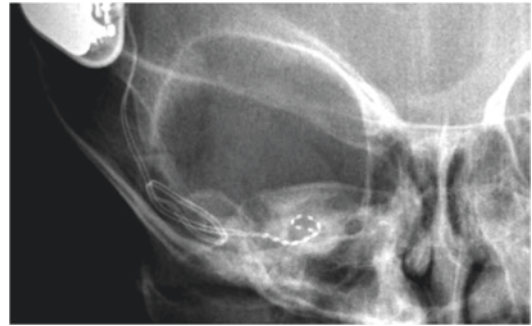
Case 26.6. Postoperative X-ray showing partial insertion of FORM 24 where electrode makes one turn in the cochlea but 1/3 was out of the cochlea
